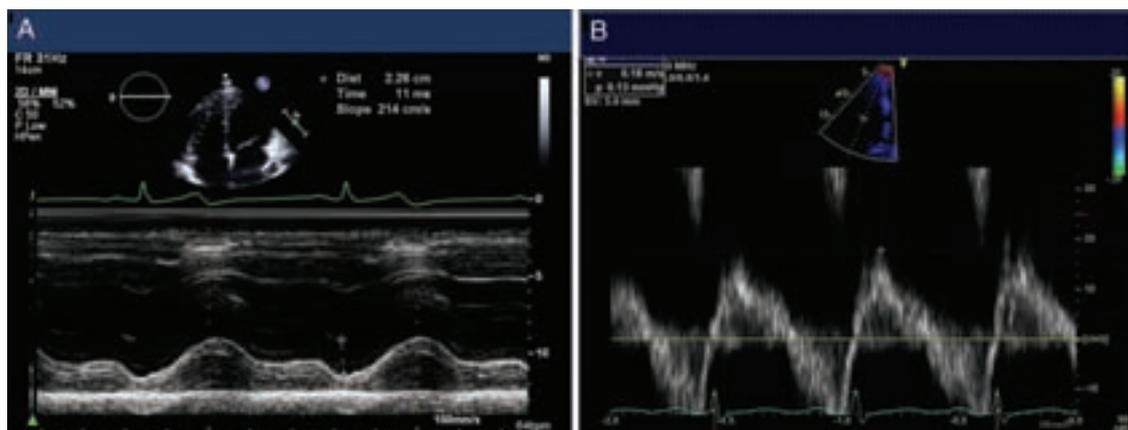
(A) Tricuspid annular plane systolic excursion (TAPSE) obtained from an apical chamber view in patient receiving anthracycline-based therapy. The TAPSE is normal, measuring 2.26 cm (abnormal < 1.6 cm). (B) Pulse Doppler peak systolic velocity at the tricuspid valve annulus in a patient 6 months after completion of trastuzumab-based therapy. The measurement is normal at 18 cm/sec (abnormal < 10 cm/sec).
